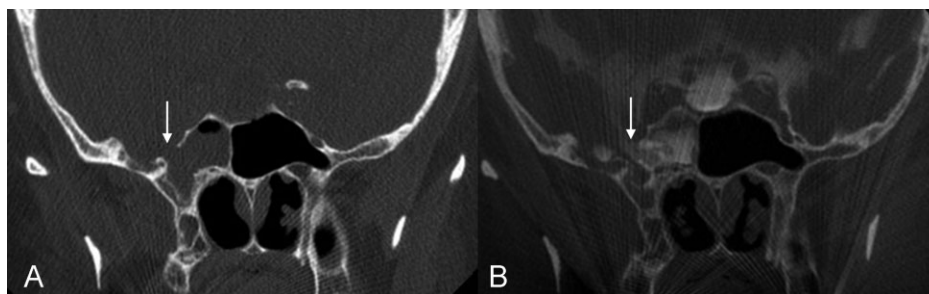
Cerebrospinal fluid leak. (A) The coronal computed tomography image shows a bony defect of the right sphenoid sinus (arrow). (B) The coronal computed tomography image from a cisternogram shows leakage of contrast into the right sphenoid sinus through the bony defect.
